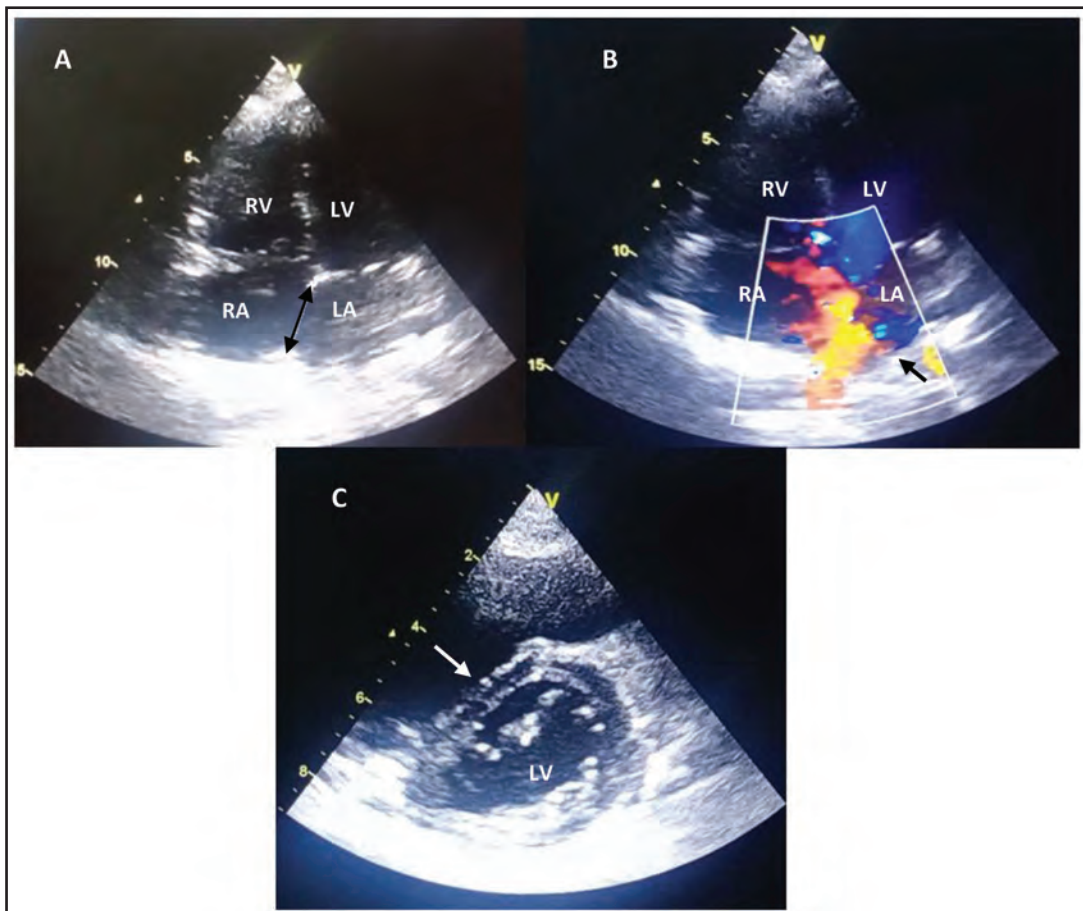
Transthoracic echocardiogram. (A) ASD [double-headed arrow] with dilated RV and RA. (B) ASD with prominent left to right shunt on colour doppler USG [black arrow head] (C) Dilated LV with septal flattening. [white arrow head] ASD=atrial septal defect; LA=left atrium; LV=left ventricle; RA=right atrium; RV=right ventricle
